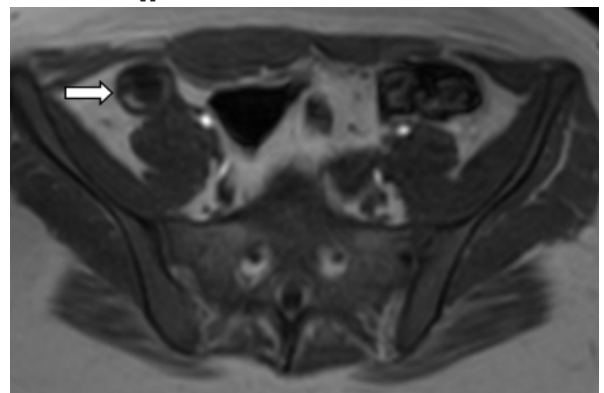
T1 MRI sequence images of pelvis showing right ovarian teratoma
